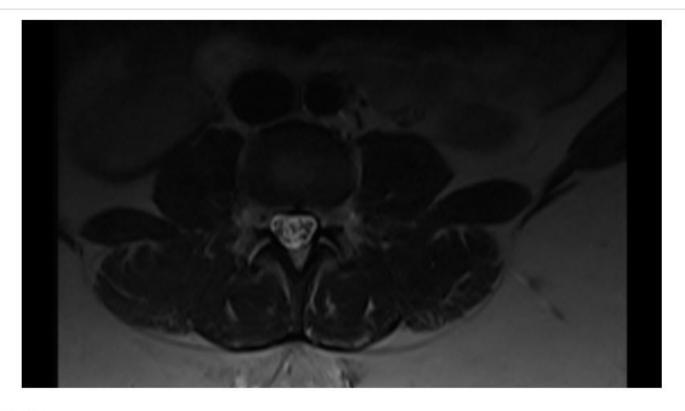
Axial MRI Image
